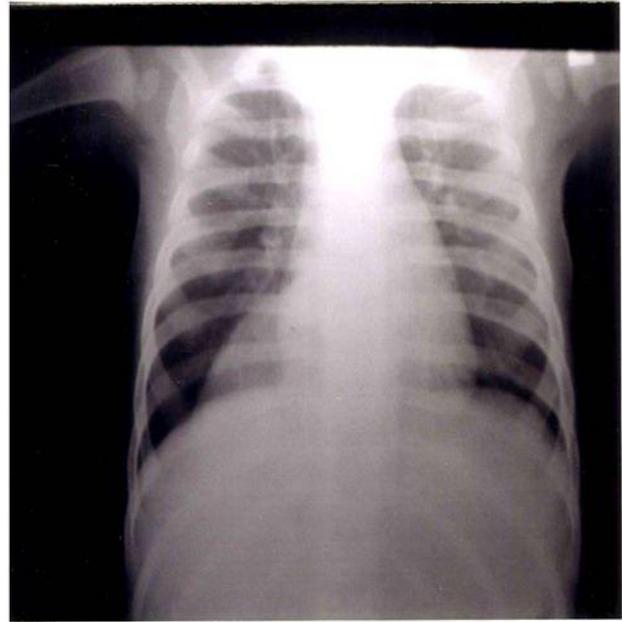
Chest radiograph showing a homogeneous opacity in the retrocardiac mediastinum and absence of fluid level in left hemidiaphragm
